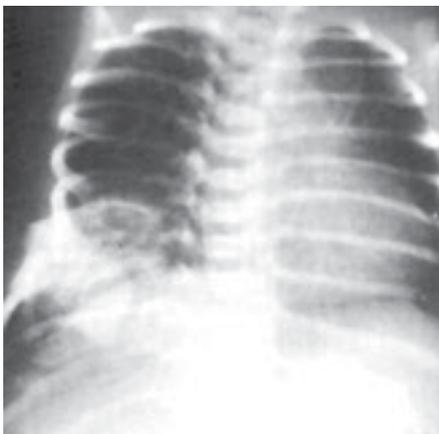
Chest wall hamartoma. X-ray of a newborn showing a lesion in the right lower rib cage, involving several ribs and projecting into the chest cavity.
